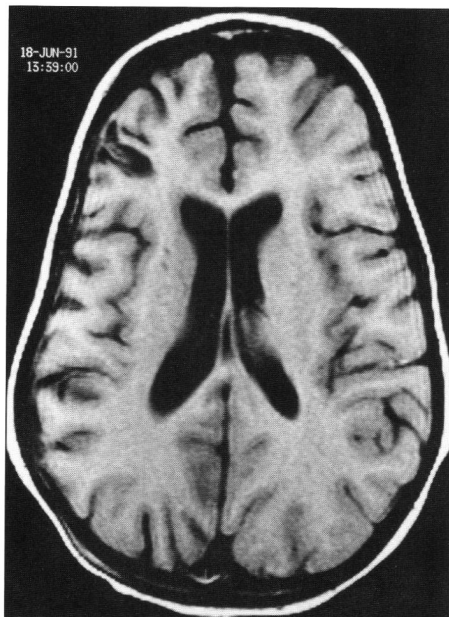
T1-weighted brain MRI in transverse plane demonstrates unilateral reduction in hemispheric parenchymal volume on the right. Note that sulci are larger on the right and that the right lateral ventricle is slightly more prominent.
